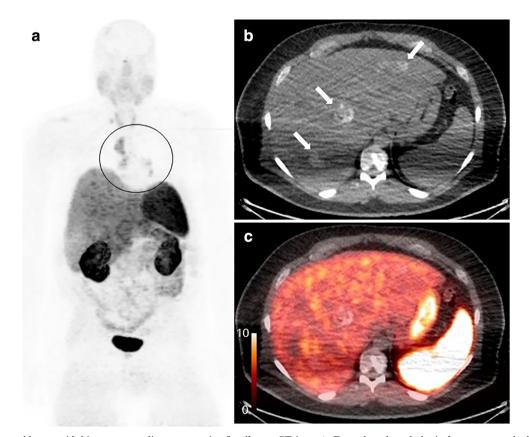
A 50-year-old man with biopsy-proven liver metastasis of welldifferentiated neuroendocrine tumor (WHO grade 2). ⁶⁸Ga-DOTATATE PET/CT was performed 3 months after liver biopsy. A maximum intensity projection image suggested multiple lymph node metastases with elevated ⁶⁸Ga-DOTATATE uptake in bilateral hilum and mediastinum (a, black circle). Although multiple liver metastases with partial calcification were detected in non-contrast CT images (b, white arrows), these lesions did not show significant ⁶⁸Ga-DOTATATE uptake (c, fused PET/ CT image). Even though pathological assessments had not been performed for the thoracic lymph nodes, size increase both in hepatic and nodal lesions was confirmed on the follow-up CT study (39.8% increase in the sum of diameters based on RECIST 1.1 criteria). Thus, in this case, tumor progression was confirmed 136 days later. Volumetric parameters calculated from ⁶⁸Ga-DOTATATE PET/CT can be underestimated in such a case expand the value of these scans in the management of such patients.
